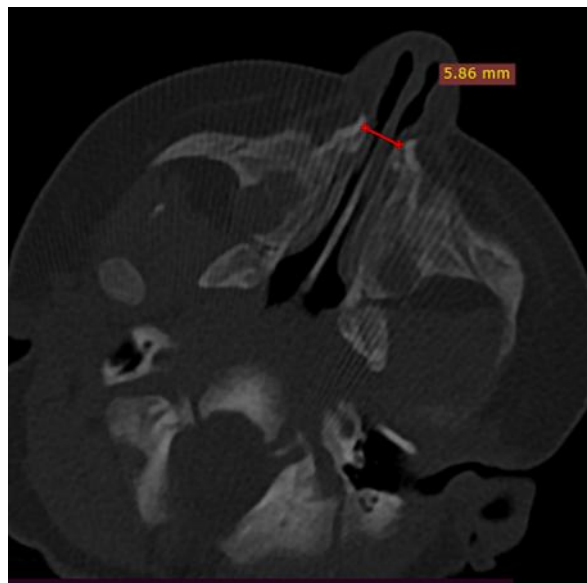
axial section of a CT scan of the facial bone in a bone window passing at the height of the choanae showing bilateral thickening of the nasal process of the maxillary bone reducing the lumen of the piriform orifices
